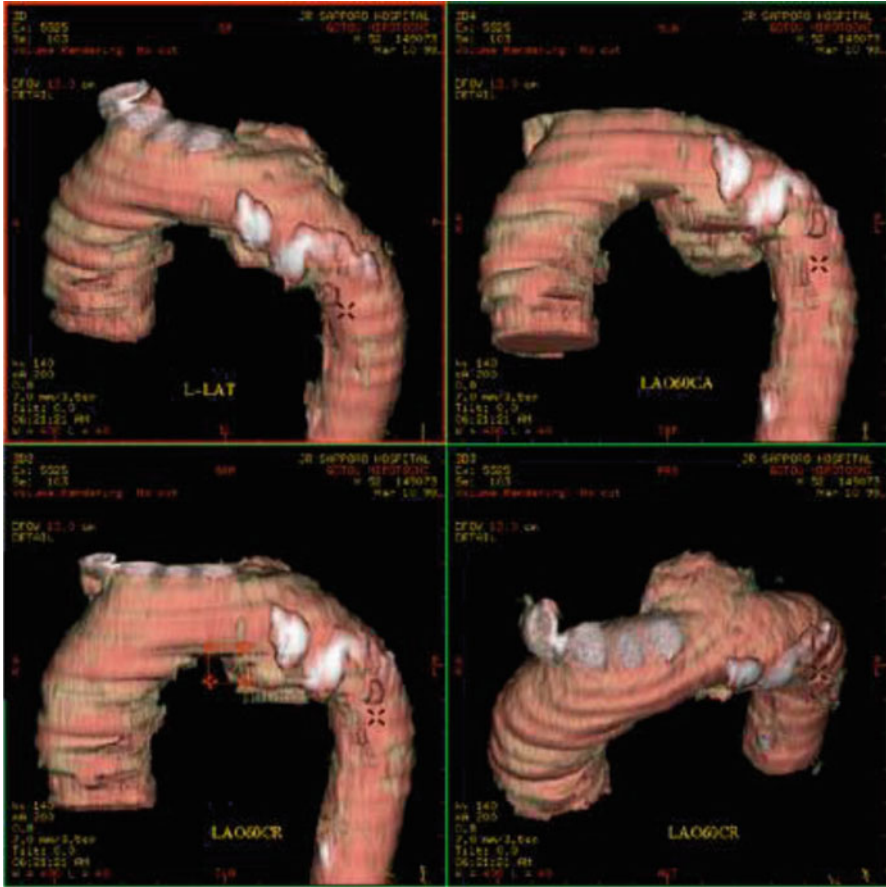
Staircase artifacts in CT image
